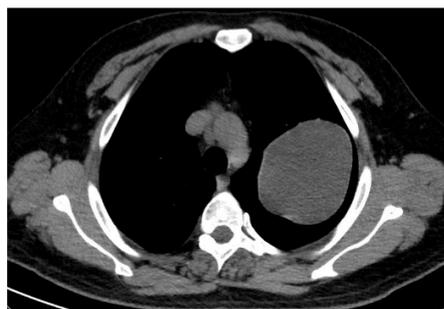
The thoracic CT image of the cyst in the left superior lobe
